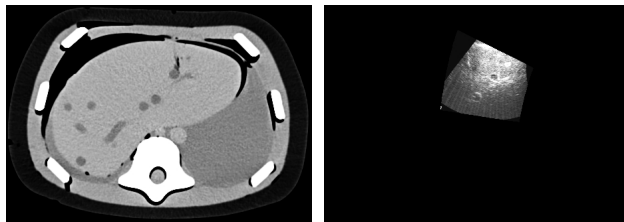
2D section of volumetric CT and US scans as used in the experiments
